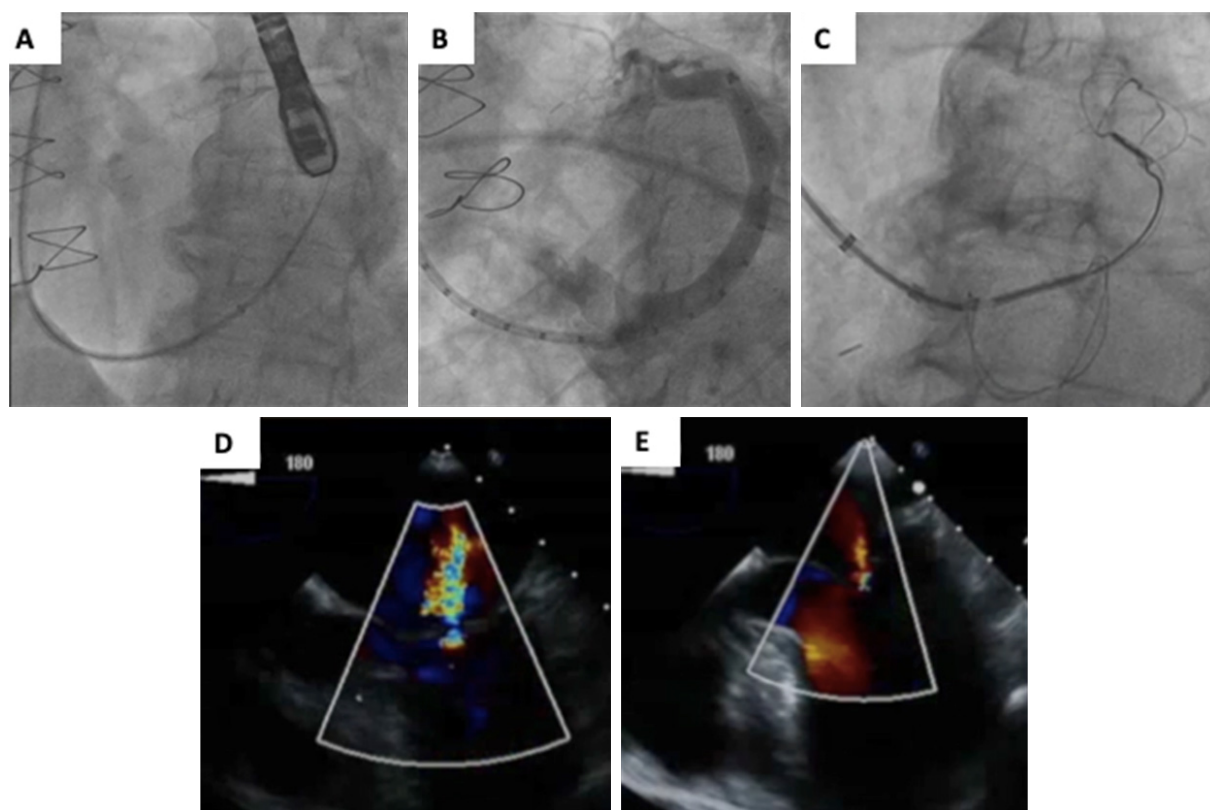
Procedural guidance of Coronary Sinus Annuloplasty. After cannulation of the CS, a delivery catheter is positioned distal in the CS/GCV (A), as close as the antero-lateral commissure of the MV; quantitative venography (B) and pre-procedural CT allows for selection of the appropriate implant size. After deployment of the distal anchor of the device and application of manual traction, the proximal anchor is deployed (C); reduction of the septo-lateral dimensions and MR downgrading are finally assessed by fluoroscopy and color Doppler imaging: pre-procedural (D) and post-procedural MR (E). CS: coronary sinus; GCV: great coronary vein; CT: computed tomography; MV: mitral valve; MR: mitral regurgitation
